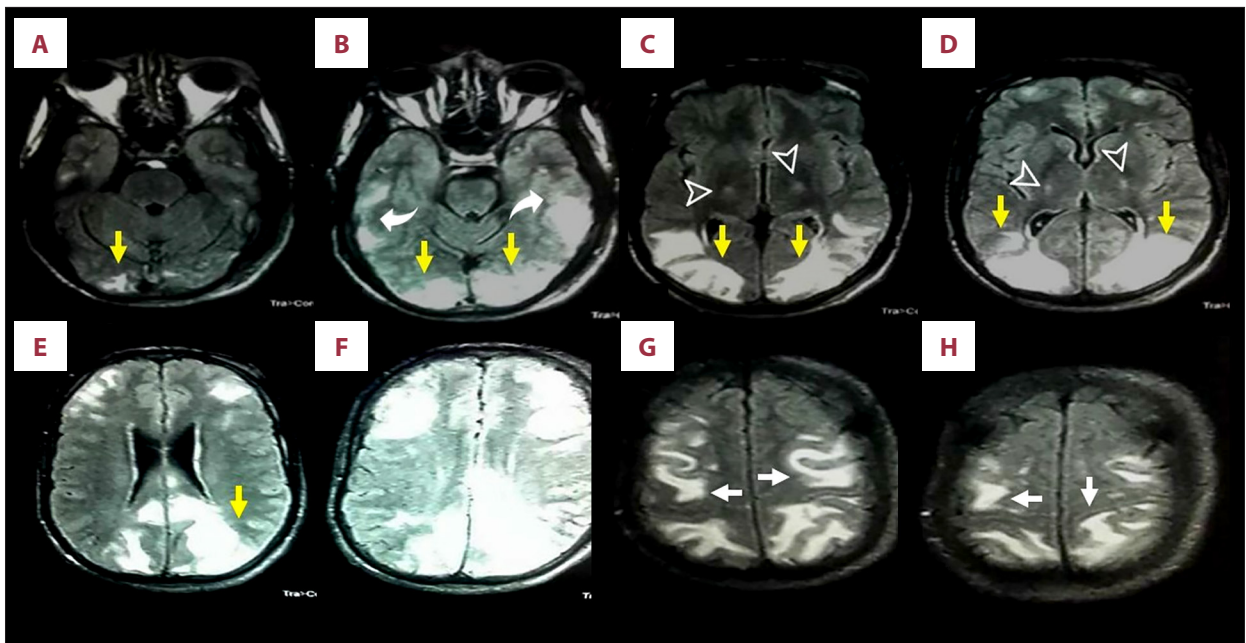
Axial T2-weighted and FLAIR MRI images of the brain (A-H) demonstrate the previously noted subcortical white matter abnormalities in both occipital lobes (yellow arrows), now extending to the parietal (white arrows) and inferior temporal lobes (white curved arrows). Additional bilateral basal ganglia hyperintense foci are observed (arrowheads). These changes are relatively symmetrical and correspond to increased T2/FLAIR signal intensity, in keeping with vasogenic edema. The remainder of the brain parenchyma appears unremarkable.
